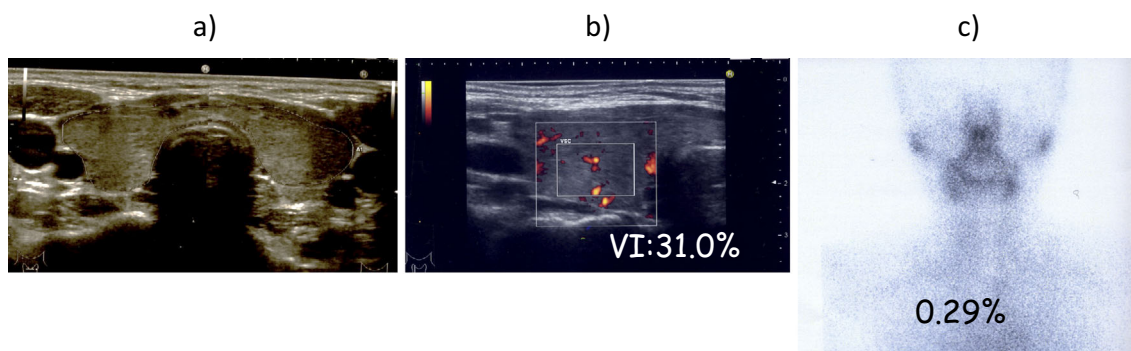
An ultrasound of (a) B-mode and (b) color Doppler (power mode) and (c) a thyroid scan with ^{99m}Tc .
